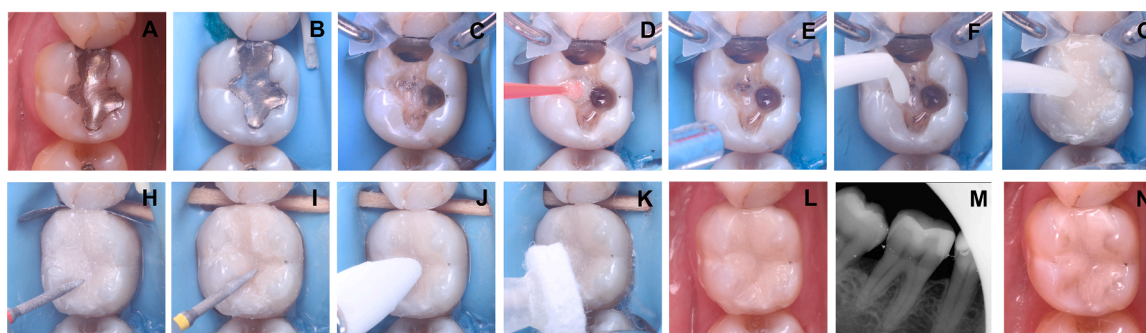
Restorative procedure. In A, a lower left first molar is shown with a defective mesion-occlusal amalgam restoration. In B depicts the tooth after rubber dam installation, and in C, the restoration has been removed and the matrix has been placed in position. Stela primer was applied (D), followed by solvent evaporation (E), and insertion of Stela Capsules (F and G). Sculpting began with coarse (H) and fine (I) diamond tips, followed by finishing (J) and polishing (K). In L shows the final restoration after 1-week of evaluation (baseline), as well as the final radiography (O). In the final picture (P), it is possible to see the clinical performance after 6 months.
